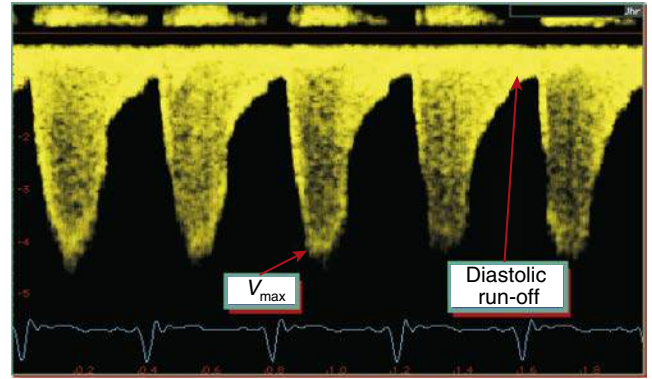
Continuous-wave Doppler recording from the suprasternal view in an adult with significant re-coarctation, showing a peak systolic velocity greater than 3 m/s and a high-velocity flow continuation persisting during diastole. (Courtesy Dr. M. Vogt, German Heart Center, Munich, with permission.)
